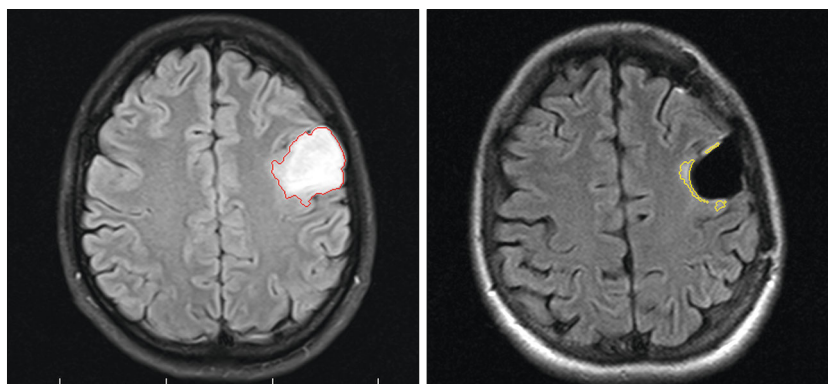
Left-sided frontal grade II oligodendroglioma. Tumour volume segmentation in pre-operative (left) and postoperative (right) axial FLAIR MRI images. The red and yellow lines show the segmentation borders.
